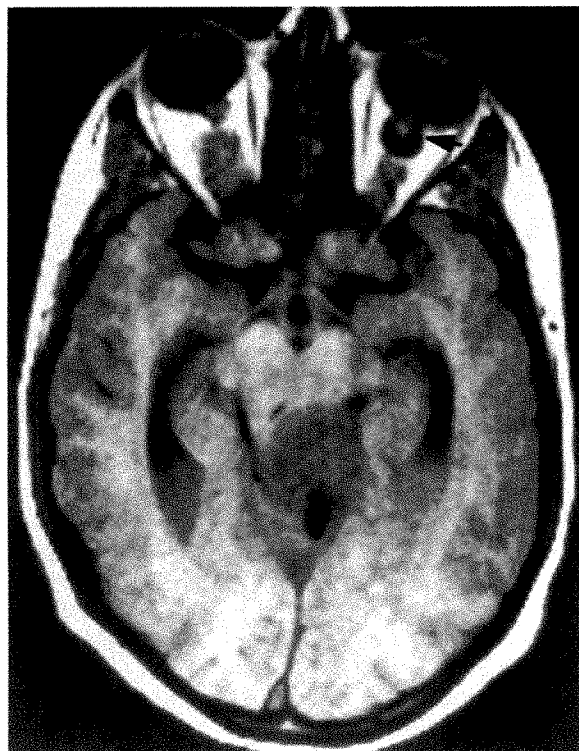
(Imes and Hoyt). Case 1. T_1 -weighted axial magnetic resonance image. Anteriorly in the left optic nerve, an area of low signal intensity surrounds a core of higher signal intensity (arrow).
